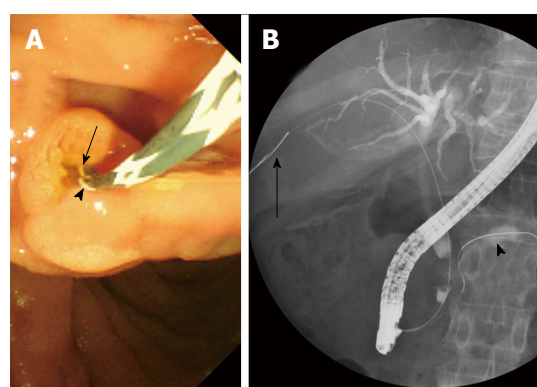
Although it has thinness of 0.025-inch (0.63 mm), its special processing method ensures rigidity equivalent to that of 0.035 inch (0.89 mm). A: 0.025-inch guidewire (GW) VisiGlide2™ placed in the bile duct (arrow)/pancreatic duct (arrow head). The visibility is good under endoscopy; B: 0.025-inch GW VisiGlide2™ placed in the bile duct (arrow)/pancreatic duct (arrow head). The visibility is good under radiography.
